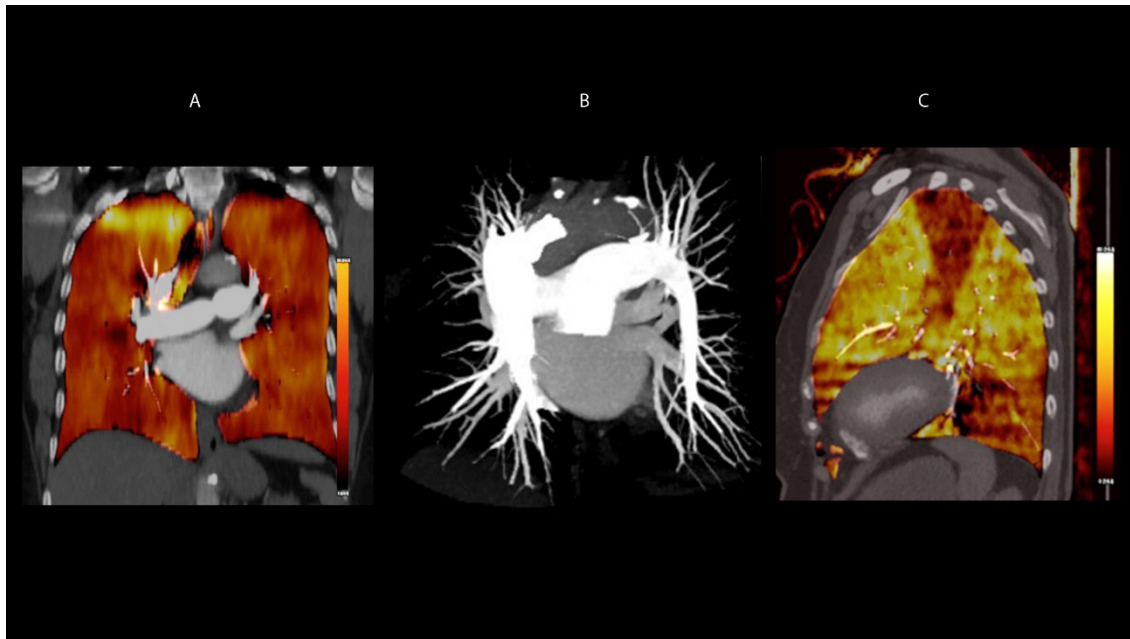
Dual-energy computed tomography pulmonary angiography. A: iodine-enhanced map reflecting the homogeneous distribution of contrast material within the lung parenchyma; B: MIP reconstruction in CT angiography. Dual-energy CT combines functional information with anatomical angiographic images. C: iodine-enhanced map of dual-energy CT in another patient, showing wedge-shaped perfusion defects in the left upper and lower lobes, compatible with pulmonary infarctions. Angiographic images (not shown) confirmed the diagnosis of acute PE.
